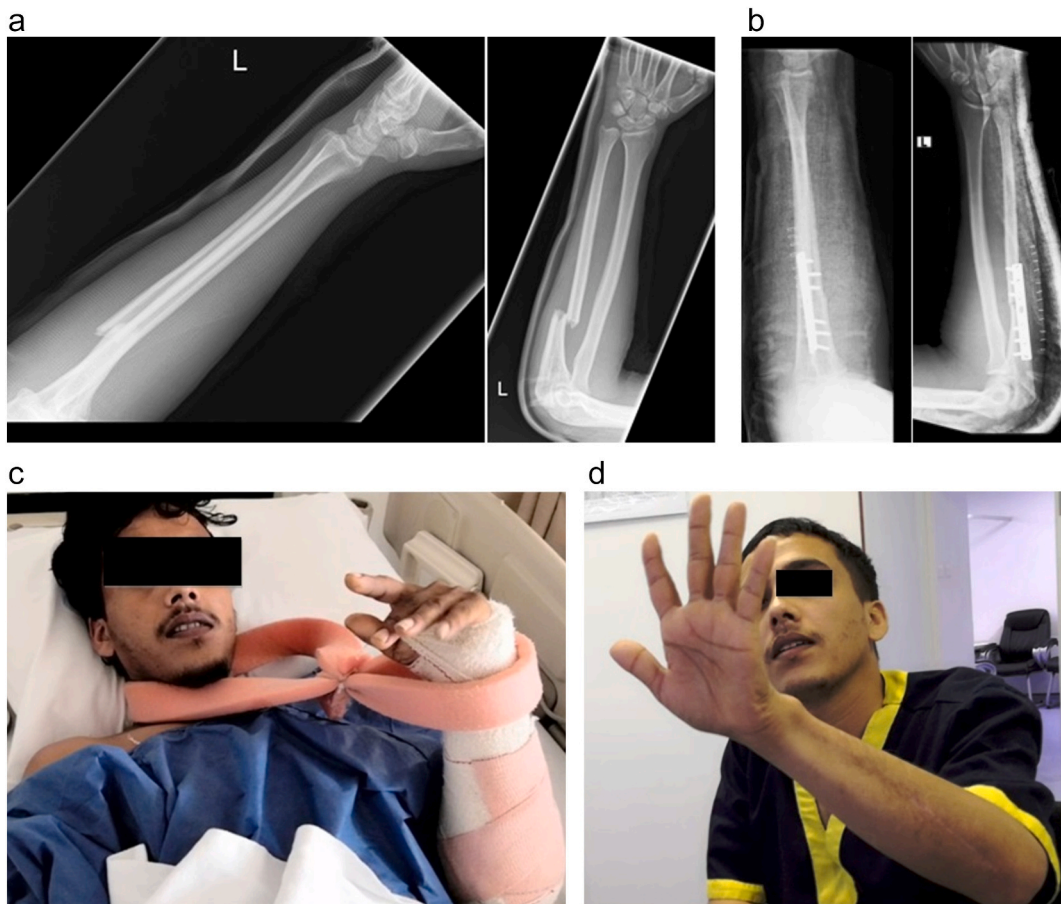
a – Injury radiographs showing closed left Monteggia fracture-dislocation
